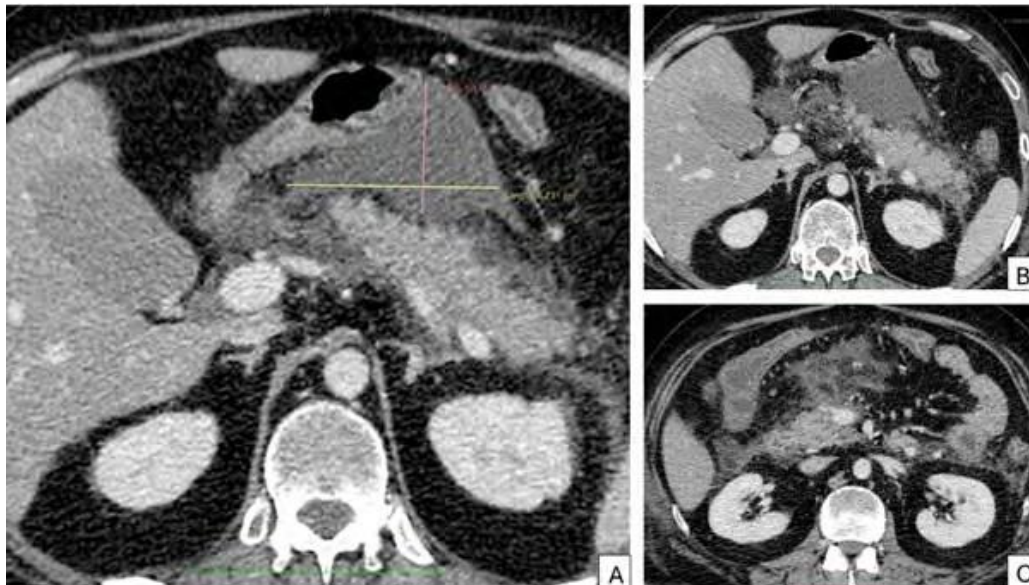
Abdominal CT performed in the emergency department– A. Axial section showing the formation of a collection behind the stomach, measuring ~8/5 cm; B. Axial section in venous phase demonstrating enlargement of the hypo-enhancing pancreas, with infiltration of the surrounding fat and small strands of oedema; C. Axial section showing important infiltration of the mesenteric fat, as well as smaller strands of fluid in the renal fascia and surrounding the intestinal loops.
